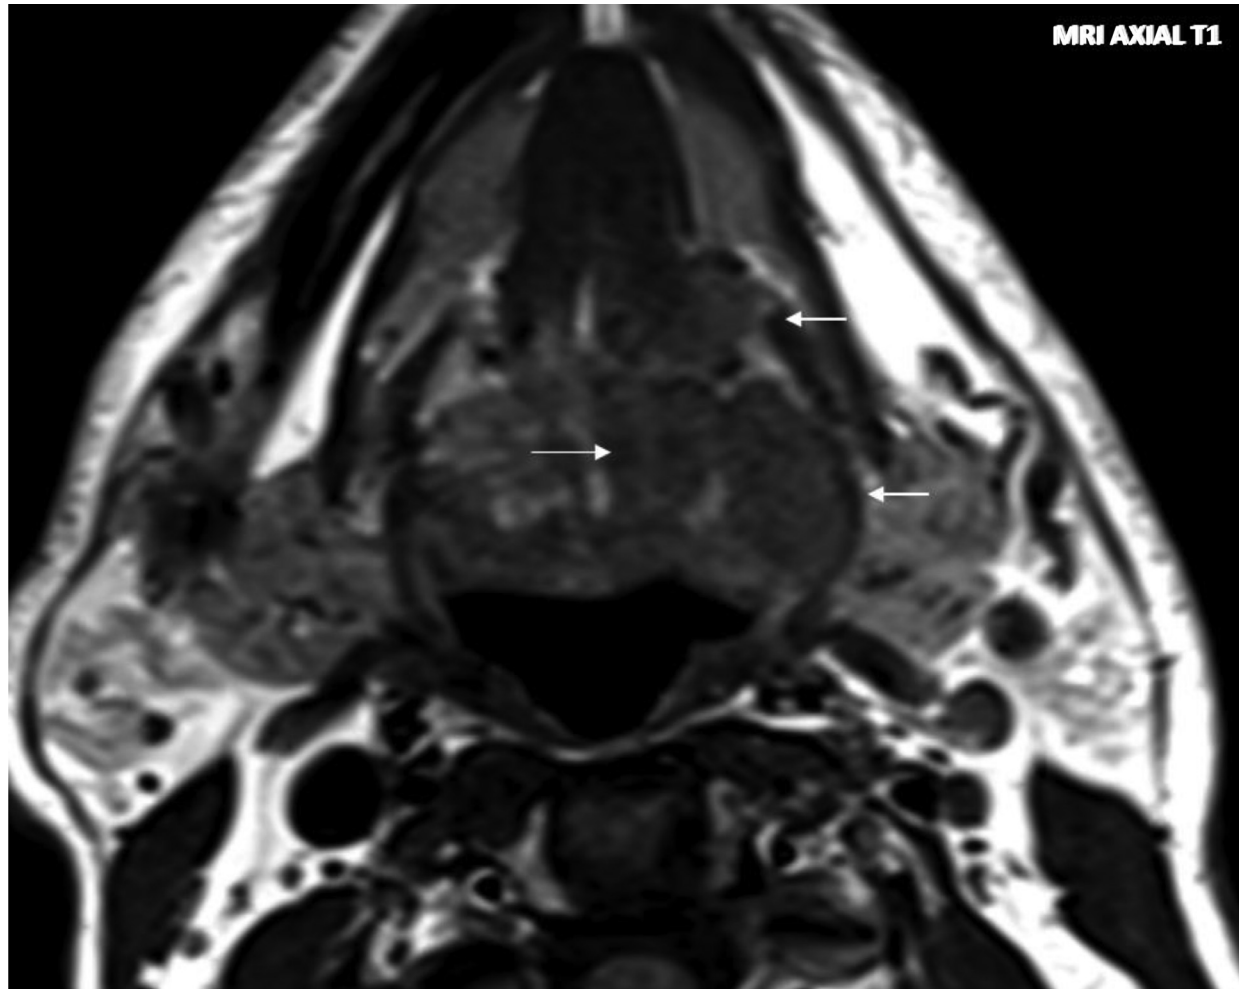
MRI: Axial T1 sequence. Three well-defined T1 hypointense lesions in the left tongue.
